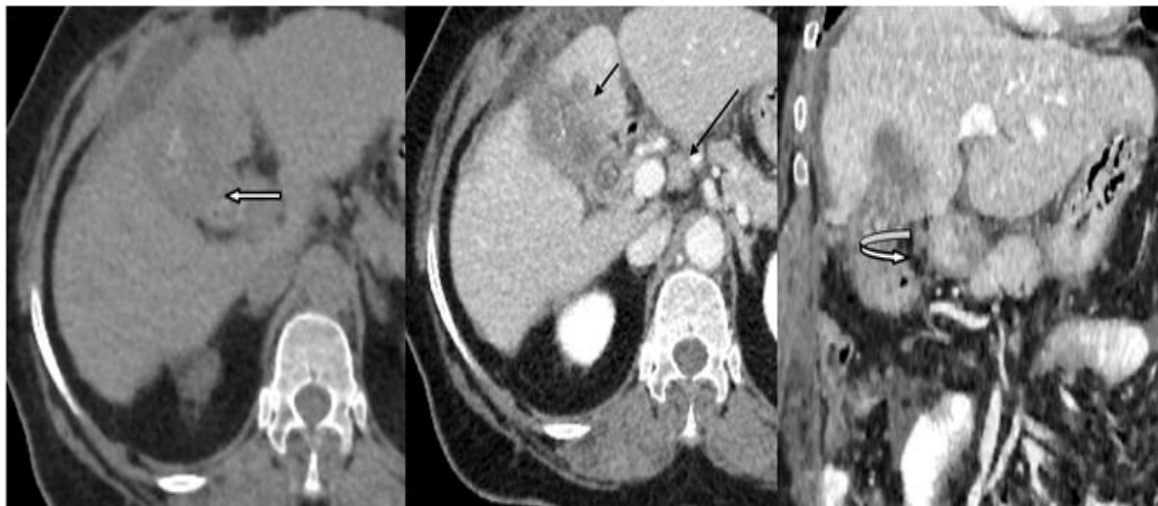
45 years old, female; Plain CT Scan abdomen; shows ill-defined irregular hypodense soft tissue mass replacing gall bladder with presence of two large intralesional hyperdense calculi (white arrow). Figure 5b- Contrast enhanced CT Scan abdomen; shows heterogeneously enhancing mass replacing gall bladder infiltrating adjacent liver parenchyma (black small arrow), enlarge periportal lymph nodes (long black arrow)) and omental infiltration. Figure 5 c- Contrast enhanced CT scan abdomen with coronal reconstruction shows better depiction of infiltration of hepatic flexure colon (curved white arrow).
